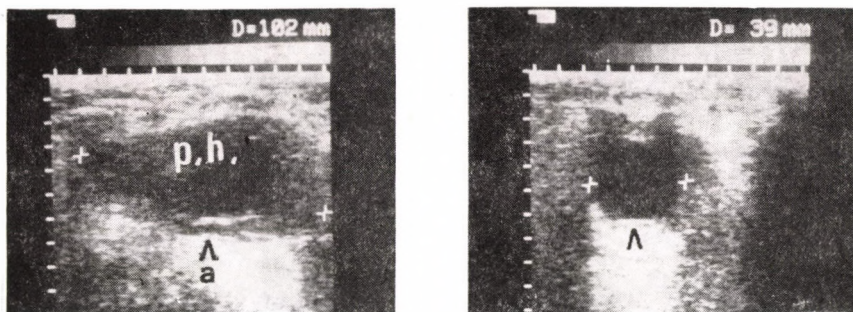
Longitudinal (on the left) and transverse (on the right) sonograms of a left inguinal pulsating haematoma (p.h.) arising some weeks after a femoropopliteal bypass. The central echo-free region is well visible as well as the dorsally located artery (a)
